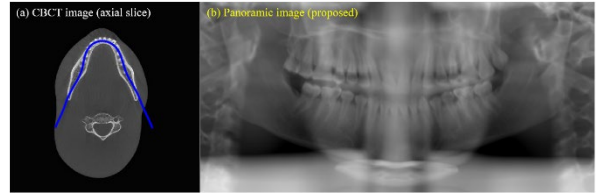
Experimental results: (a) dental arch extracted through Bézier curve, and (b) proposed panoramic image reconstructed using the CBCT projection data before applying an appropriate image enhancement process.
